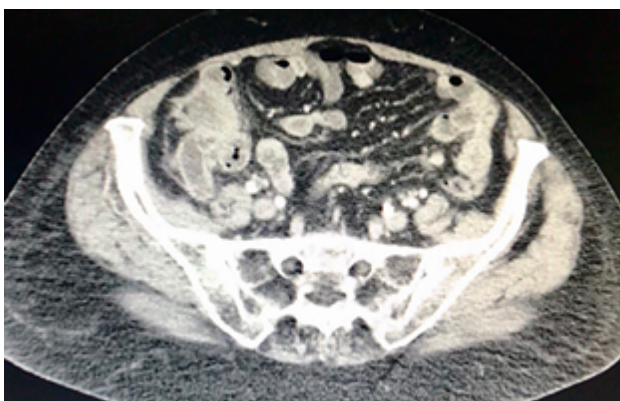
CT scan of the abdomen showing cecal and appendicular thickening with local lymph node involvement.
